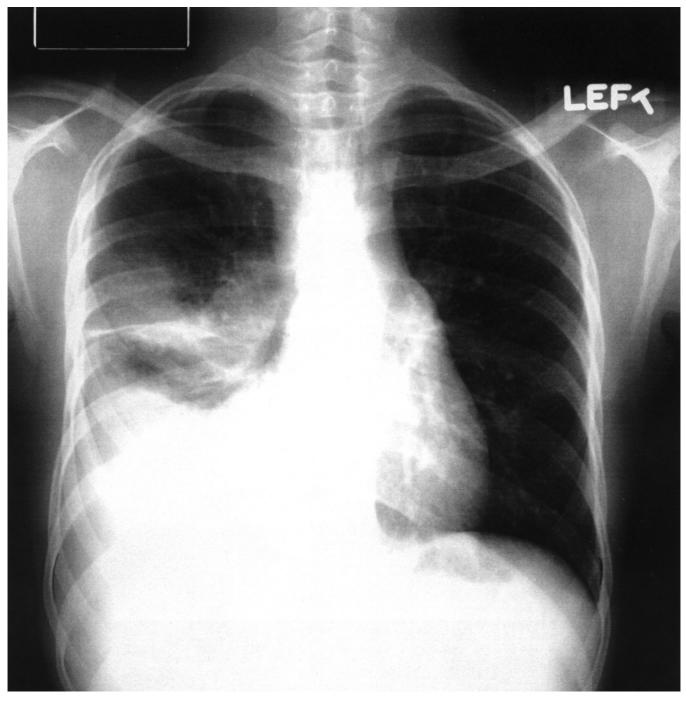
A 22 year old man admitted to the hospital for fevers, cough, chest pain, cervical adenopathy and weight loss. His chest radiograph shows right paratracheal and hilar adenopathy, a right pleural effusion with loculation and adjacent in Itrate. He was found to have HIV infection with a CD4 cell count of 133 per cubic milliliter. Cultures of sputum, pleural uid and lymph node all grew *M. tuberculosis*. He was treated with standard therapy and responded well, and antiretroviral therapy was initiated after two months without complication.
